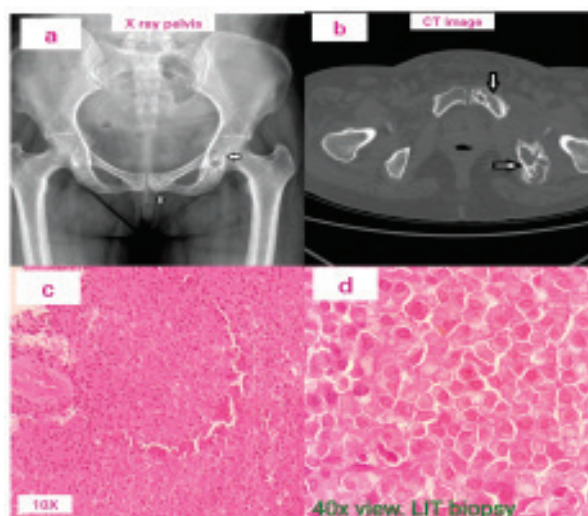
X-ray pelvis (2a); CT image show expansile lytic lesions in left ischial bone and acetabulum (2b); Left ischial tuberosity biopsy section with plasmacytoid cells (2c & 2d).
